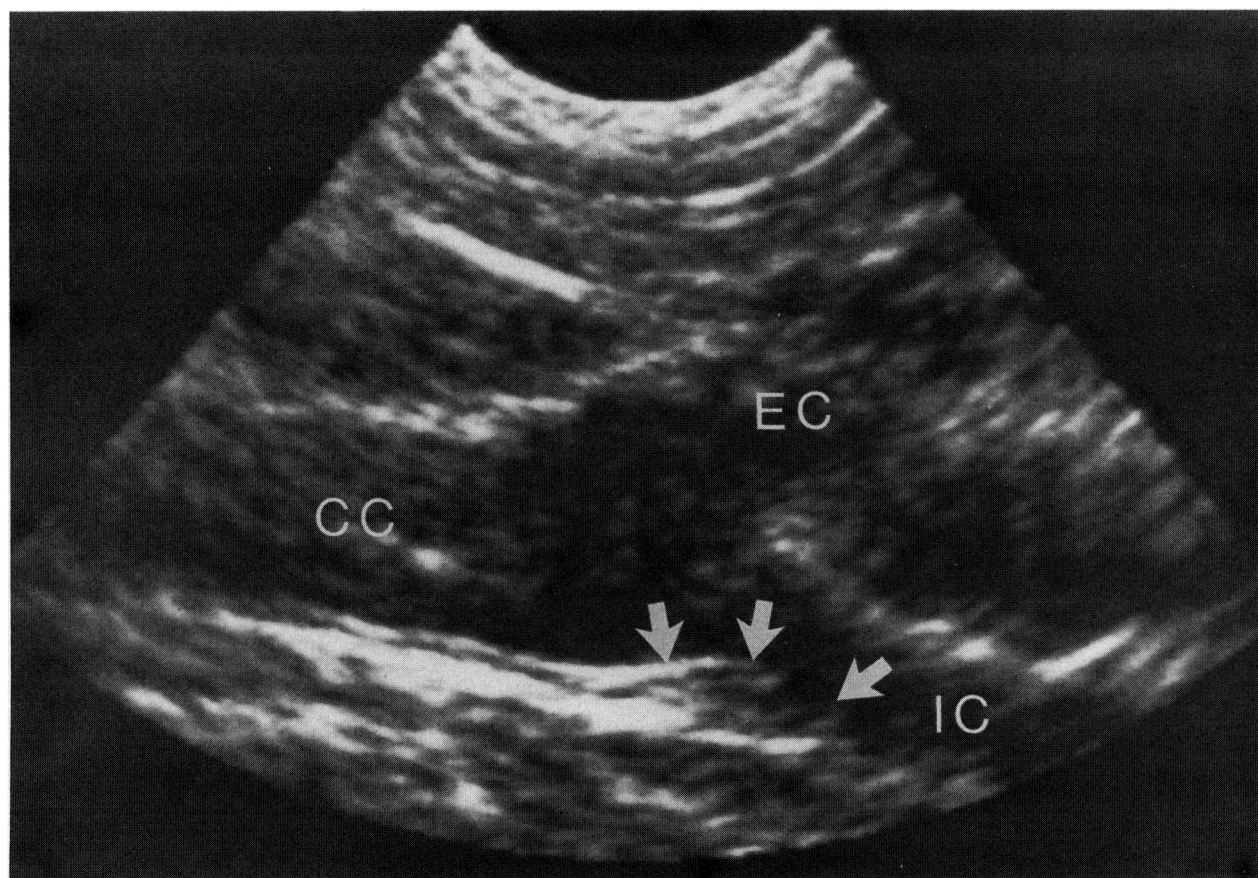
Two-dimensional ultrasound image of the distal common carotid artery (CC) and bifurcation into the external (EC) and internal (IC) carotid arteries. The presence of a plaque within the carotid bulb and proximal internal carotid artery is indicated by the arrows.
